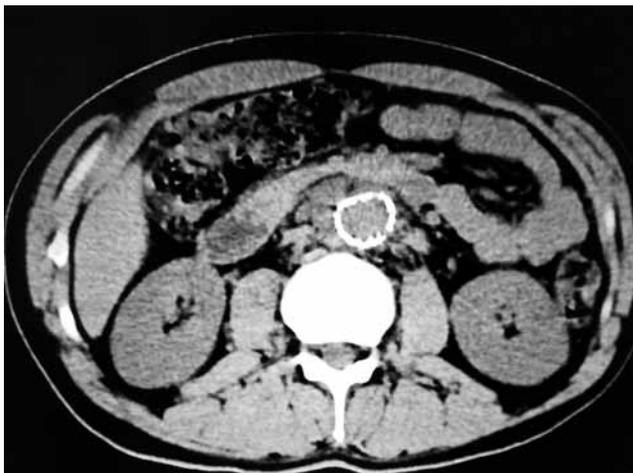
The air and abscess detected by computed tomography around the stent graft.
